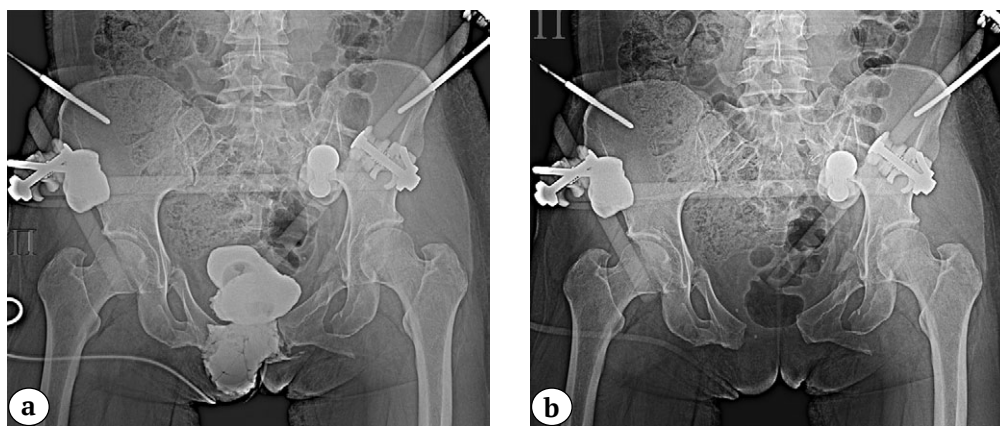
Pelvic X-ray in the anteroposterior view: symphyseal disruption with significant diastasis and fractures of both pubic bones (a); cystogram showing extravasation of contrast beyond the bladder contour (b)
